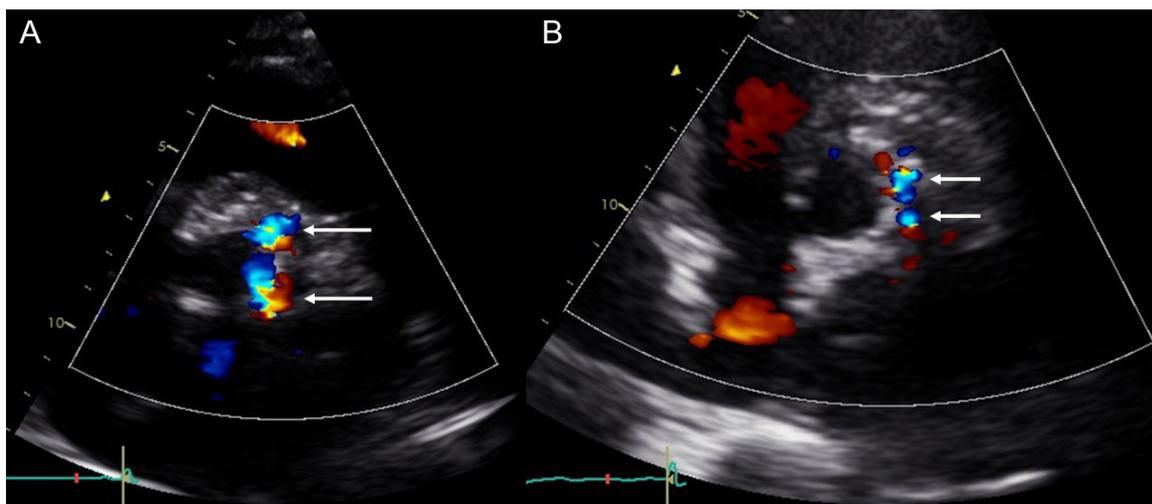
(A) Echocardiographic image of the CoreValve THV in parasternal short axis view at baseline. The arrows denote 2 jets of PVLs along the THV circumference from 1 to 4 o'clock positions. (B) Echocardiographic image of the CoreValve THV in parasternal short axis view showing a reduction in PVL (arrows denote PVL from 2 to 3 o'clock positions) post-procedure. PVL: paravalvular leak; THV: transcatheter heart valve
